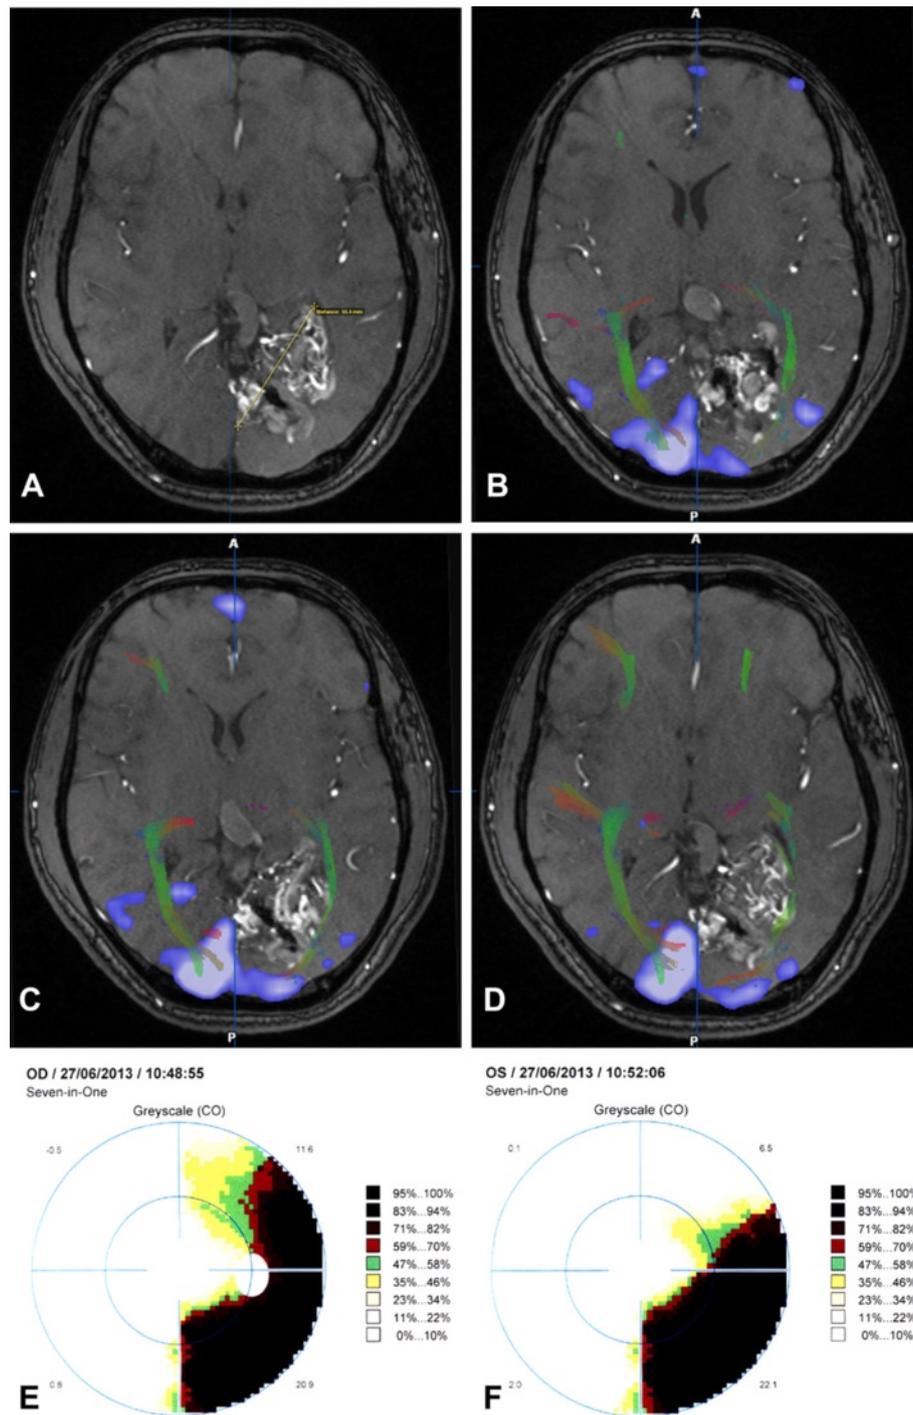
Case 3. A 42-year-old male with a history of hemorrhage. a Enhanced structural axial T1-weighted image showing a left occipital AVM with a maximum diameter of 55.4 mm (yellow line). b–d Based on enhanced structural axial T1-weighted image, fiber tracking showing the asymmetry of optic radiation (green) and visual cortex (blue). Both the AVM-OR and AVM-VC distances were zero. The optic radiation ipsilateral to the AVM is much thinner than that of the contralateral. e–f Visual fields testing showing a homonymous partial hemianopsia
